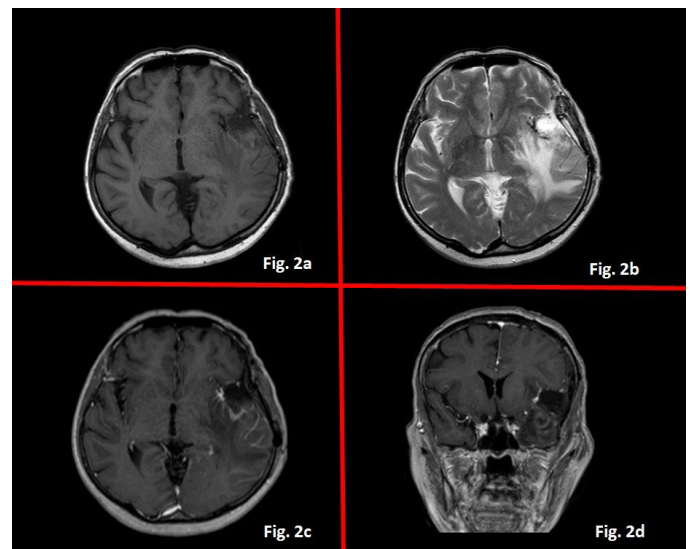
Cranial MRI of the patient after the first surgery. T1 axial (2a), T2 axial (2b), contrast-enhanced T1 axial (2c), and contrast-enhanced T1 coronal (2d) views. Gross total resection of the entire tumor is observed
